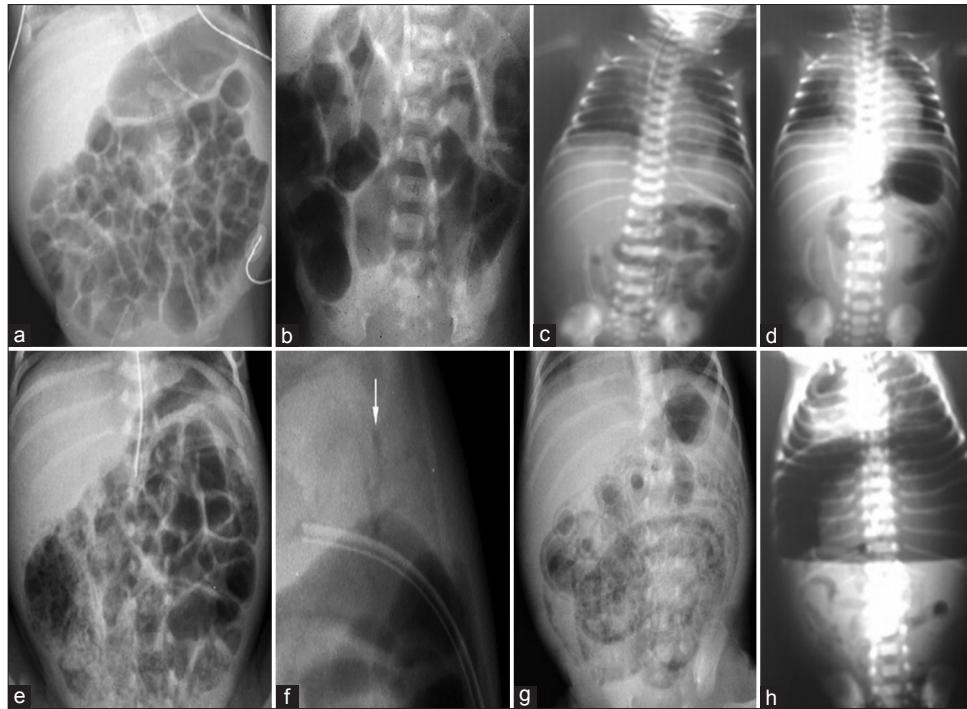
X-ray shows: (a) normal mosaic intestinal patterns, (b) abnormal distended bowel loops, (c) elongated intestinal loops, (d) gasless abdomen with distended loops, (e) pneumatosis intestinalis, (f) portal venous gas, (g) soapy bubble appearance, (h) pneumoperitoneum
